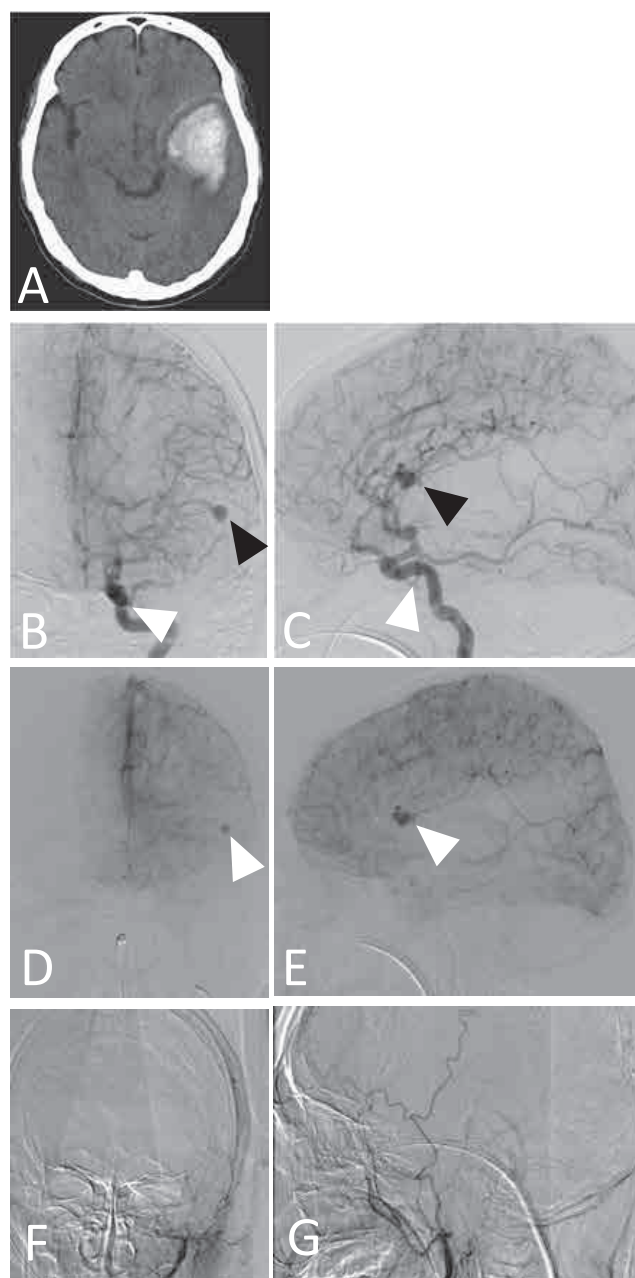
(A) Computed tomography (CT) image before attempts intravascular surgery showing a left temporal-parietal subcortical hematoma. (B~E) Cerebral angiography reveals that a dural arteriovenous fistula (DAVF) is fed by the left inferolateral trunk (ILT) of the left internal carotid artery (white arrows) and is draining into the left sphenoparietal sinus with reflux into the left superficial middle cerebral vein and a varix (black arrows), suggesting Borden type III (B, C: frontal views, D, E: lateral views). (F, G) Cerebral angiography reveals that DAVF is not fed by external carotid artery (F: frontal view, G: lateral view).
